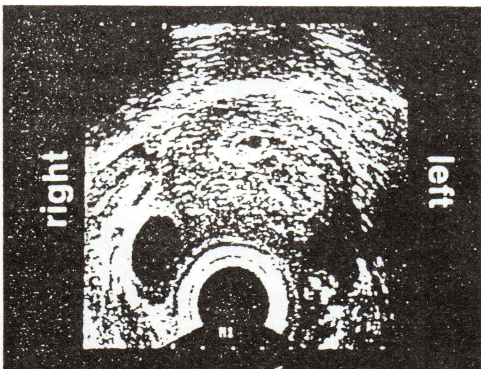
Transvaginal sonography : classification of left and right in cases of cross-section of the uterus.
